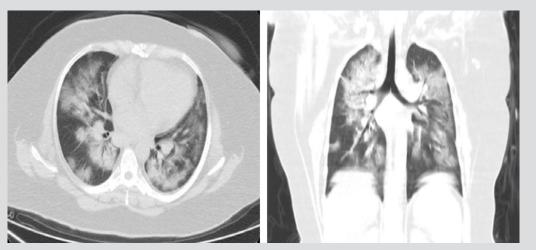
CT scan showing ground-glass opacities and consolidation
